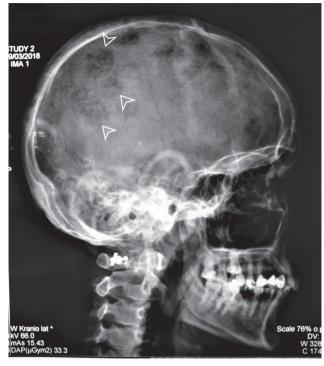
Radiograph of the skull (lateral view). Multiple radiolucent lesions are noted in the frontal and parietal bone (arrows).
